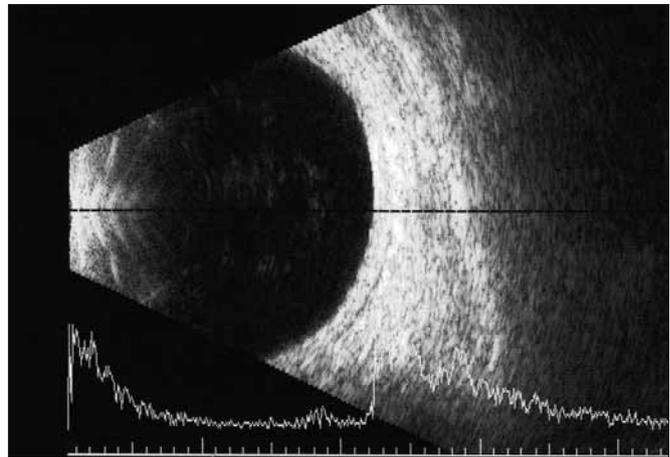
B-scan ultrasonography scan with assumed attachment of the posterior hyaloid.
